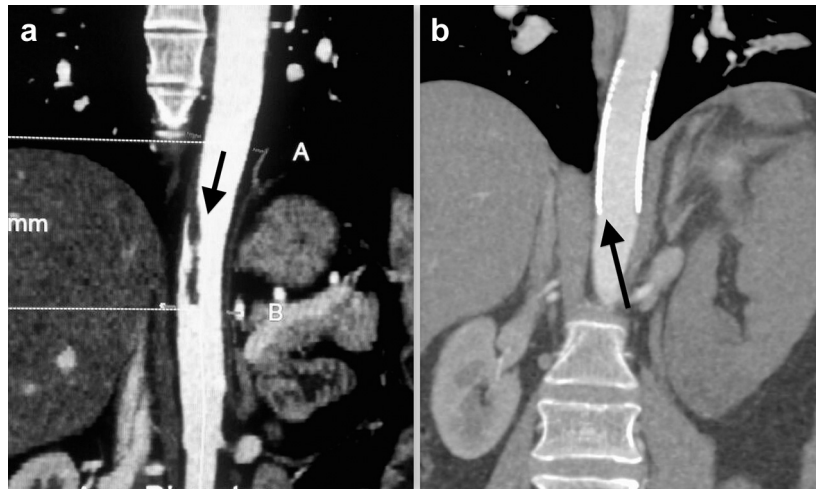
Type IIb primary aortic mural thrombus (PAMT). a, Preoperative computed tomography (CT) scan showing type IIb pedunculated thrombus. b, Six-month follow-up CT scan shows complete exclusion of thrombus by 22- × 70-mm Wallstent (Boston Scientific, Watertown, Mass).
